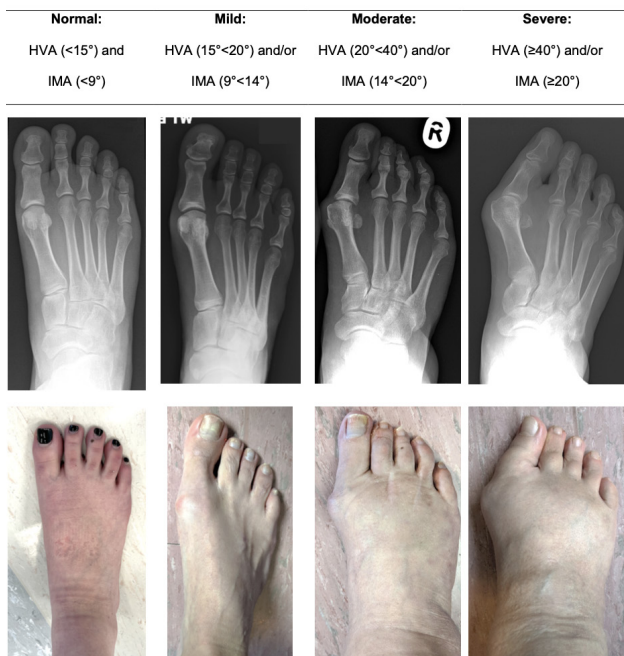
Severity of Hallux Valgus deformity classified by radiographic assessment. Images courtesy of Robbie Ray.
